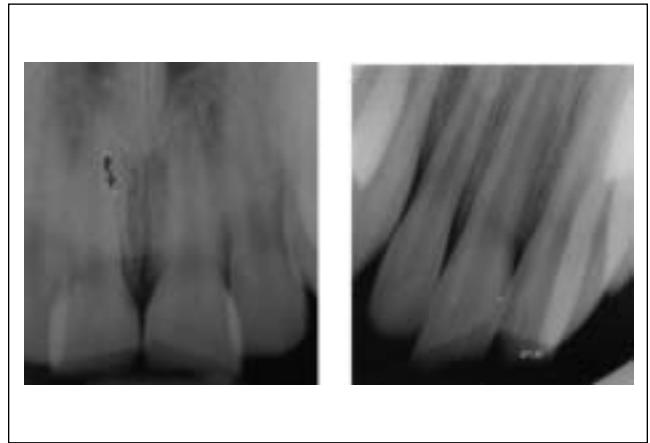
Radiographic examination of fractured 11 and 21
